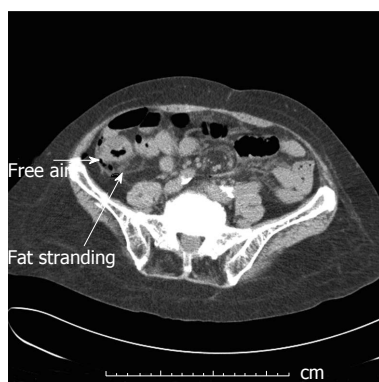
Computed tomography abdomen demonstrates free air and inflammatory fat stranding at the site of the polyp removal by endoscopic mucosal resection in the proximal ascending colon. Those features are consistent with a colonic perforation.
